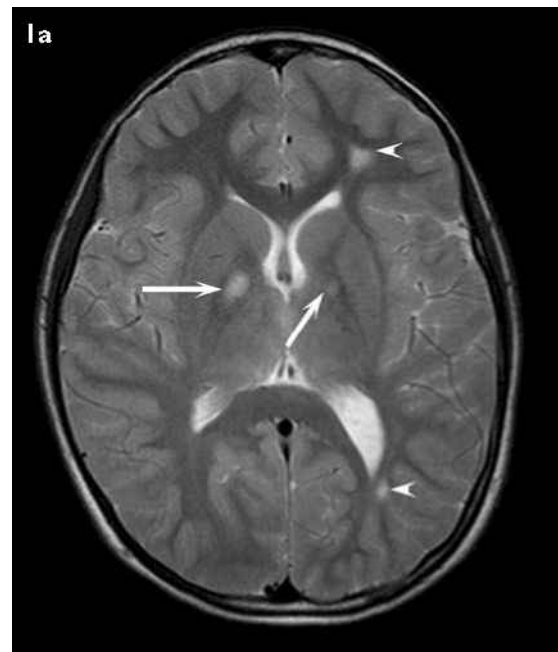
Initial MR images of the patient obtained at 7 years of age. (a) Axial T2-weighted MR image shows multiple small foci of T2 prolongation in the left frontal and occipital lobe white matter (arrowheads) as well as both globus pallidi (arrows). (b) Corresponding coronal FLAIR image shows that the left-sided white matter lesion is hypointense (arrowhead), compared to the hyperintense UBOs in the basal ganglia (arrows).
